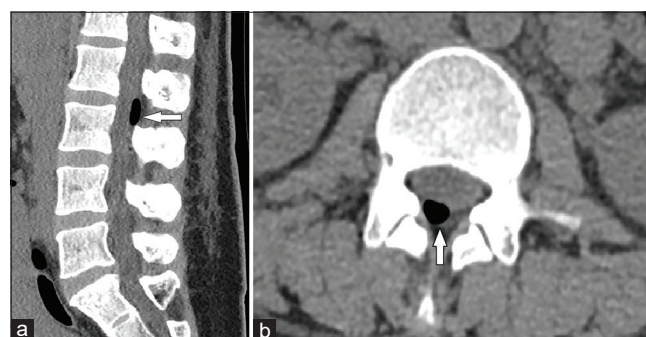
The air bubble (16.2 × 3.9 mm, white arrow) in L2-3 level epidural space on Lumbosacral spine Computed tomography on postoperative day 2. (a) Sagittal view, (b) Axial view
